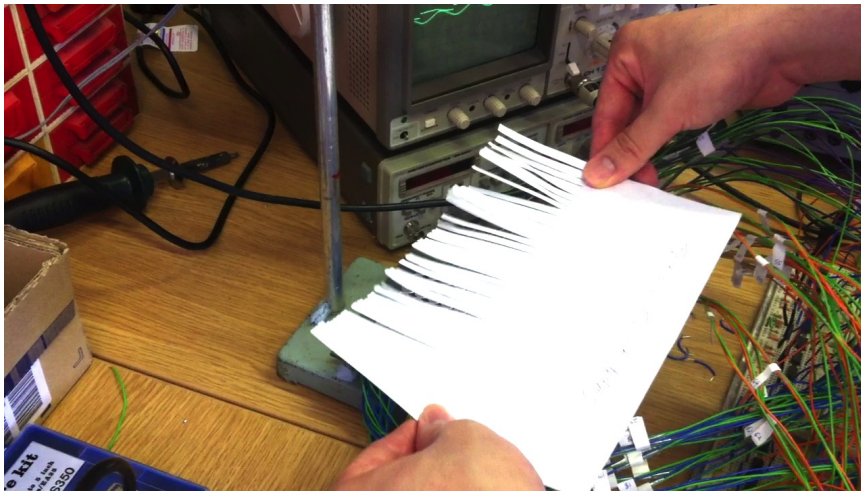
Ultrasonic focal point pushes against the paper strips
